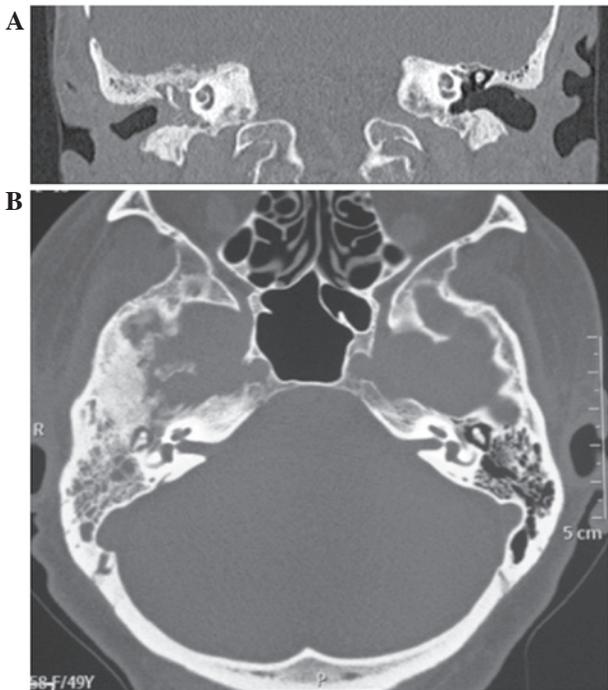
(A) Coronal and (B) axial computed tomography scans performed in November 2009 demonstrating an intratympanic mass enveloping the ossicular chain, without erosion.
